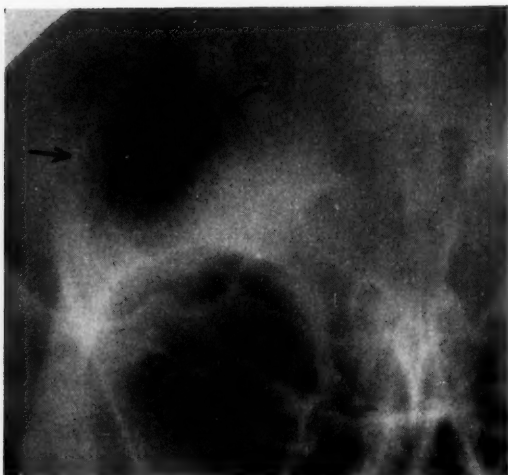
Case 1.—Anteroposterior x-ray picture.
